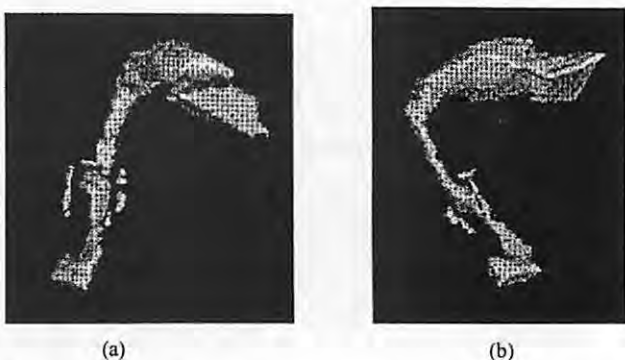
Shaded surface display (using MRI) of the vowel /a/ excluding the teeth by using the "digital cast" in Figure 2 to estimate their dimensions: a) left tilted frontal view - flat surface in the upper right portion of the picture is the mouth termination plane, b) left tilted, inferior view.
